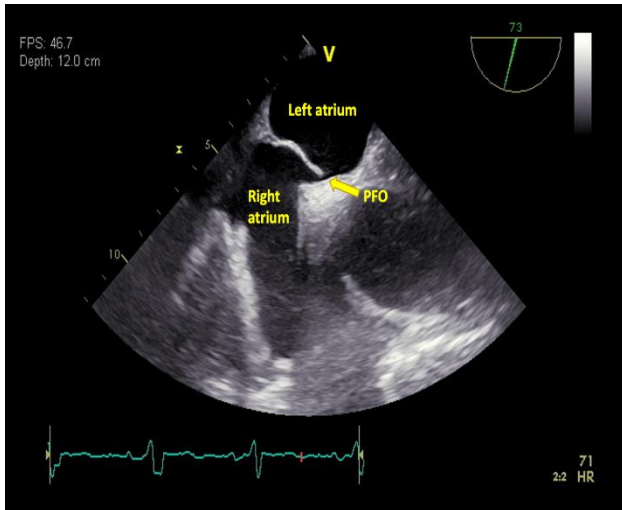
Transesophageal echocardiography in a 73° view. No evidence of thrombus.
